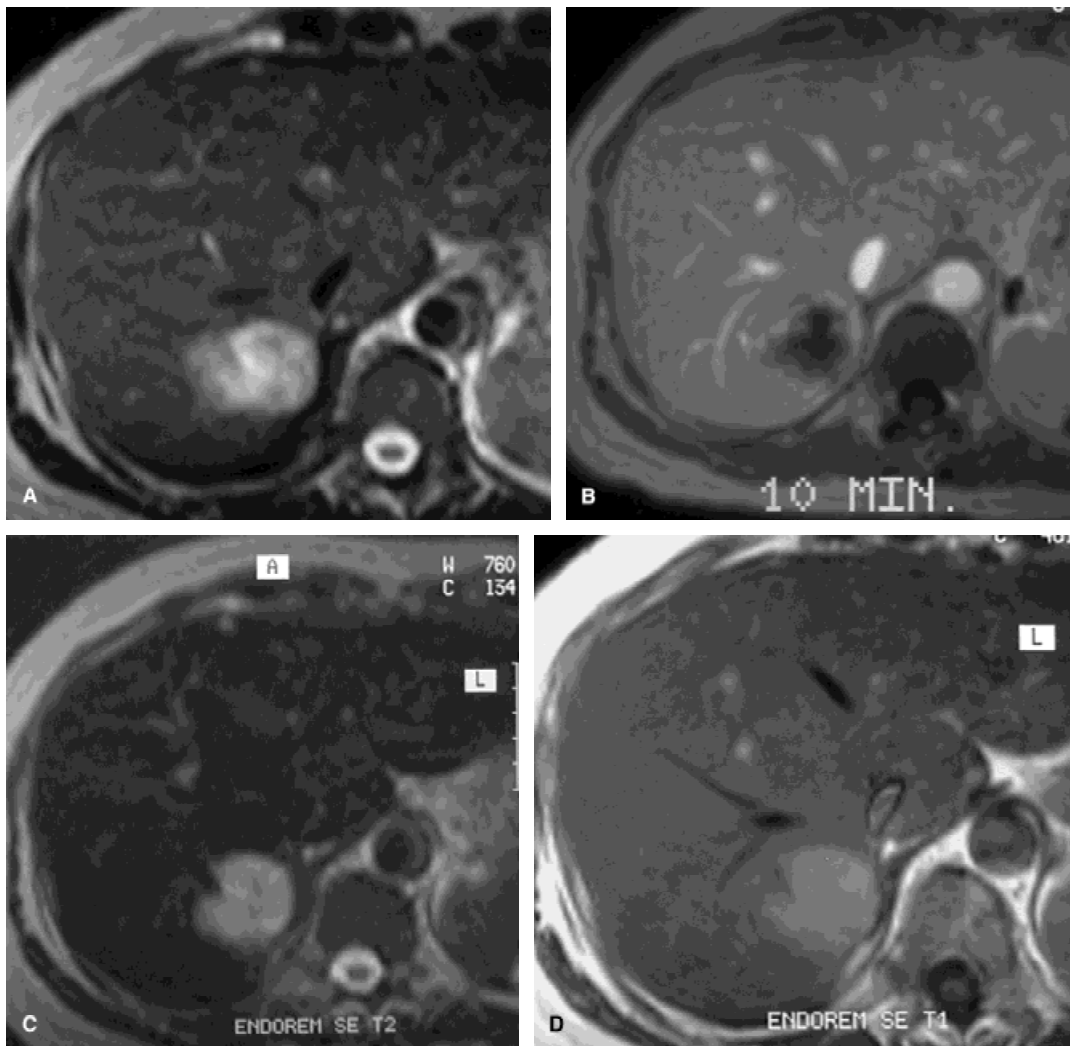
Atypical hemangioma in a 45-year-old man previously operated on for colon carcinoma. a: SE transverse T2-weighted image shows an inhomogeneously hyperintense lesion in the right lobe of the liver. During dynamic imaging with bolus administration of Gd-BOPTA (GRE transverse T1-weighted), the lesion shows a peripheral enhancement, which does not reach the center of the lesion until the distribution phase (b) and then only with slight enhancement. c: SE transverse T2-weighted images 1 hour after administration of Endorem. Homogeneous signal drop throughout the liver and the lesion. d: SE transverse T1-weighted image 1 hour after administration of Endorem. The hemangioma appears slightly but uniformly hyperintense.
